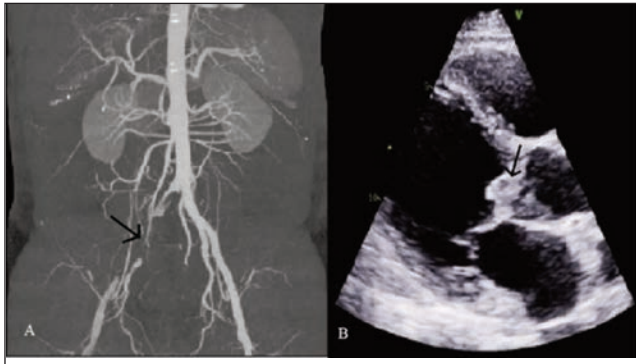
(A) Computed tomography angiogram showing complete non-opacification of the right-sided common iliac artery and complete non-opacification of the superficial femoral artery just distal to its branching of the right profunda femoris artery throughout its length (B) Transthoracic echocardiogram showing a mobile echogenic density attached to the aortic valve
